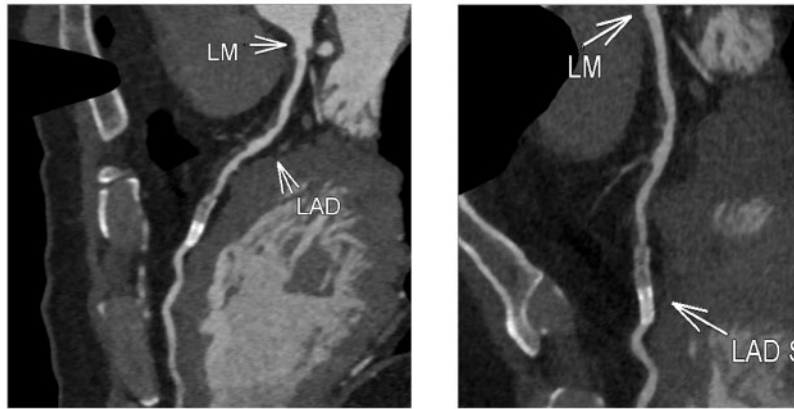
Computed tomography coronary angiogram suggests recurrent in-stent restenosis. LAD = left anterior descending; LM = left main.
